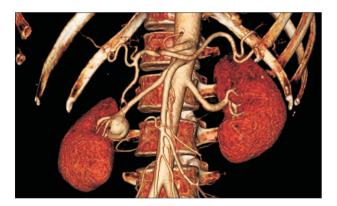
Computed tomography with 3-demensional reconstruction revealed 2.2-cm-sized renal artery aneurysm without calcification located at hilum of right kidney.
